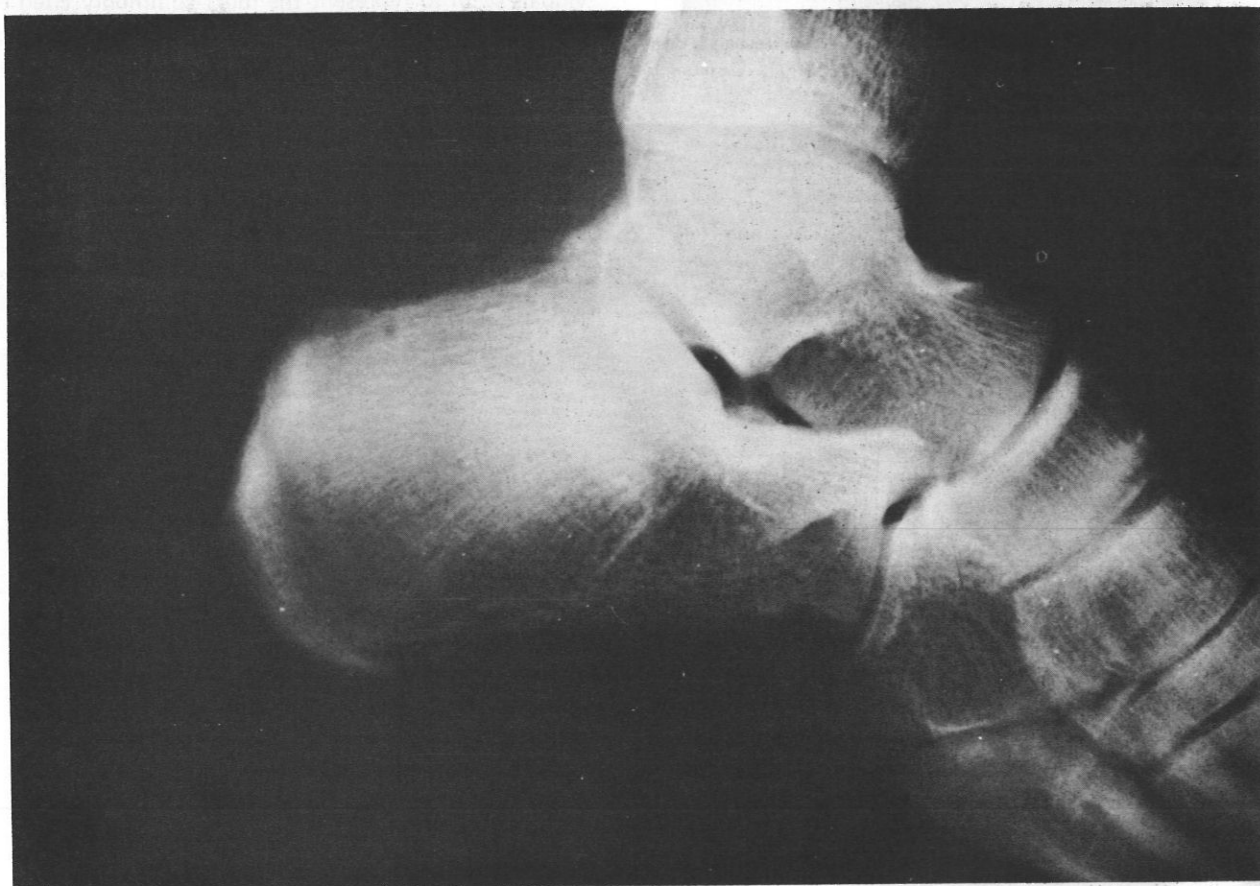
Lateral view roentgenogram of the calcaneus reveals double stress fracture.
